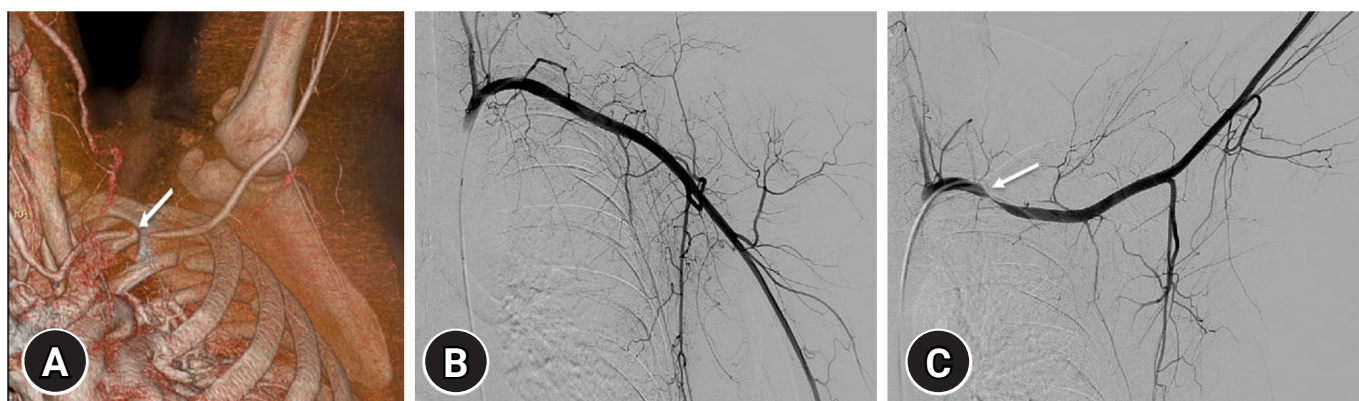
Patient images upon evaluation. (A) Computed tomography angiography reveals severe stenosis of the left proximal subclavian artery when the left arm is raised (arrow). (B) Left upper extremity angiography demonstrates that normal blood flow is maintained in the left subclavian artery when the left arm is lowered. (C) However, severe stenosis is observed proximal to the left subclavian artery when the left arm is raised (arrow).
